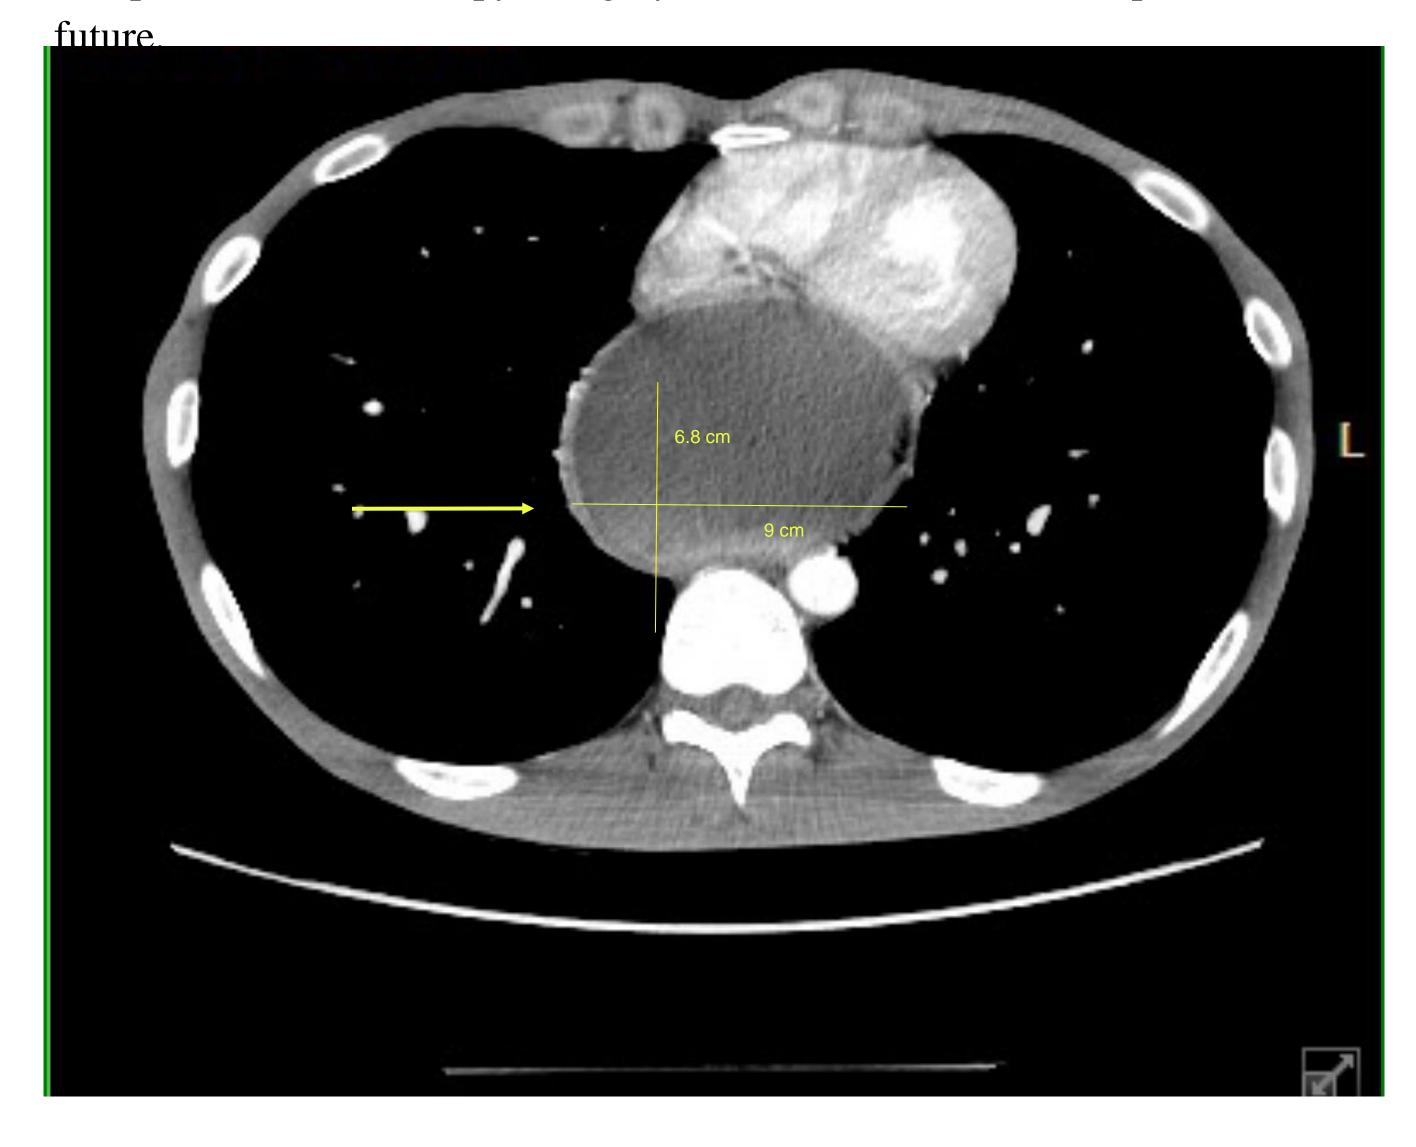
Computed tomography showing distended esophagus measuring 6.8 cm x 9 cm
